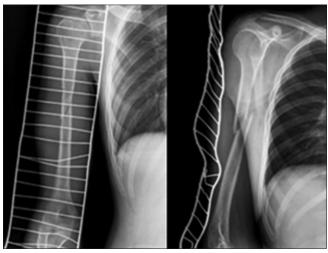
Preoperative anteroposterior and lateral plain radiograph of arm showing right humeral shaft fracture and intramedullary patchy osteoporosis
